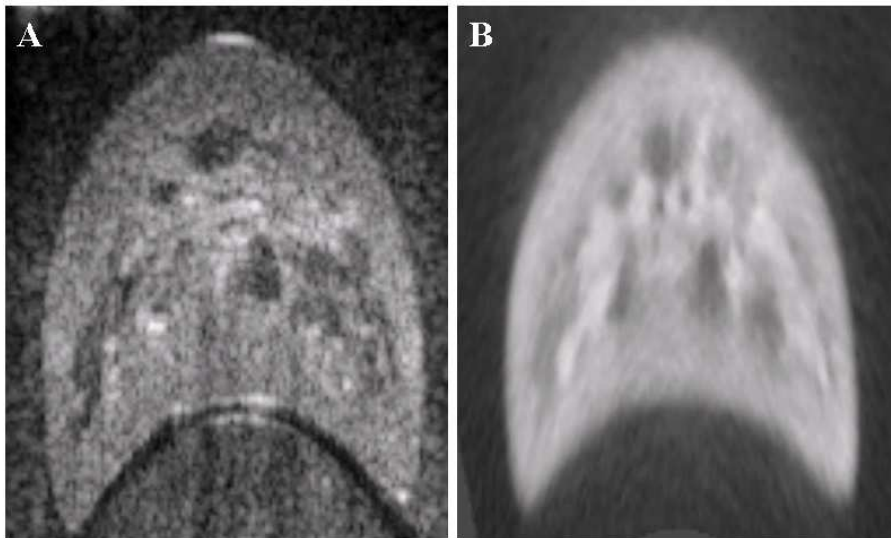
Shows the pre-scan converted US and its corresponding inverse scan converted CT. Both images are in pre-scan converted coordinates.
